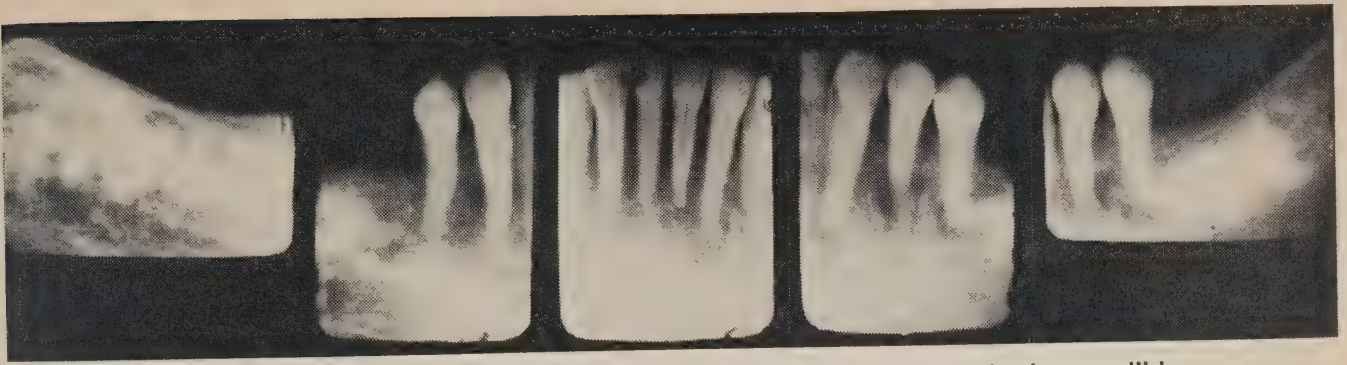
Periapical radiographs show 'cotton wool' appearance in the mandible.
